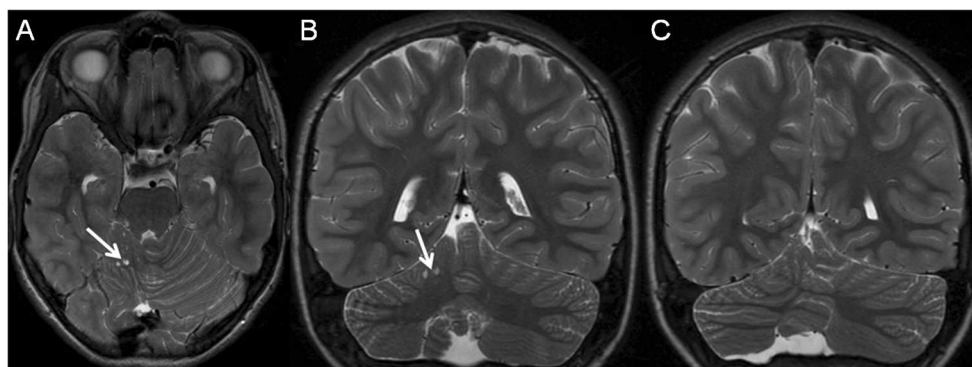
A 11-year-old girl with the history of multiple hospital admissions for functional (non-organic) complaints, including headache. The neurological examination was normal. Axial (a) and coronal (b, c) T2-weighted images show a mild reduction in volume and dysplasia
